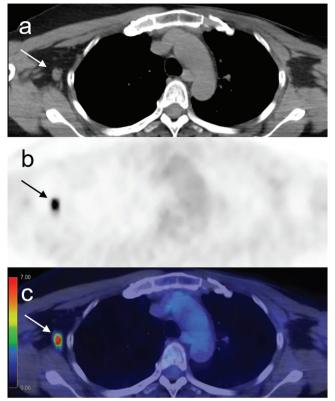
Axial CT (a), <sup>18</sup>F-FDG PET (b), <sup>18</sup>F-FDG PET/CT fusion image (c) at the axillary level. Lymph nodes with increased <sup>18</sup>F-FDG uptake [maximum standardized uptake value (SUV $_{max}$ ) 11.0] are seen in the right axilla (arrows). These lymph nodes were oval-shaped, and the hilum was seen in the largest of these lymph nodes. Their size was up to approximately 11×9 mm, which was larger than that observed on the <sup>18</sup>F-FDG PET/ CT performed a year ago. Some studies have reported that COVID-19 vaccination increases the <sup>18</sup>F-FDG uptake in the axillary lymph nodes on the vaccinated side (1,2,3,4,5,6). To date, <sup>18</sup>F-FDG uptake in the lymph nodes has been reported to have a SUV<sub>max</sub> of 4.5 and 9.4 (1,2); however, it was even higher in this case (SUV $_{max}$  11.0). Similar findings have been reported for influenza vaccinations (7,8). It is necessary to appropriately interpret these findings after injection of the influenza vaccine to avoid confusion with lymph node metastasis or lymphoproliferative diseases, such as malignant lymphoma. The same would also apply to the COVID-19 vaccination. Especially when the vaccine is injected intramuscularly on the ipsilateral side of the cancerous breast, it might be difficult to distinguish the reactive changes due to vaccination from metastasis of the breast cancer in the <sup>18</sup>F-FDG PET/CT images. Therefore, patients with breast cancer should be vaccinated in the deltoid muscle contralateral to the cancerous breast. In addition, when interpreting the <sup>18</sup>F-FDG PET/CT findings in patients who have received the COVID-19 vaccine, it should be noted that vaccination might cause increased uptake in the axillary lymph nodes on the vaccinated side. It is expected that the chances of interpretation of <sup>18</sup>F-FDG PET/CT images of patients who have been vaccinated against COVID-19 will increase rapidly. Hence, it is important to confirm the patient's recent vaccination history, site of vaccination, and the period since vaccination before the examination.
